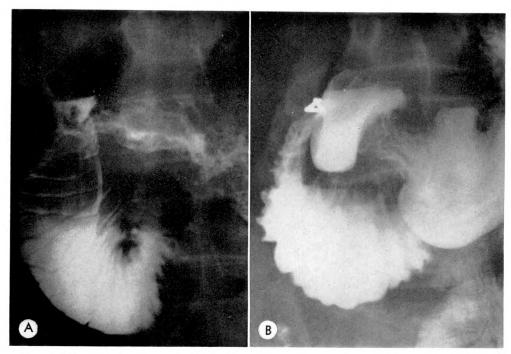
(A and B) Roentgenograms made during fluoroscopy, with the patients in upright position, are shown from the examinations of the same 2 patients as in Figure 1, A and B. Barium is seen to pool in the dependent portion of the paretic, dilated duodenum. In B, air-fluid levels are evident between the plicae circulares.
